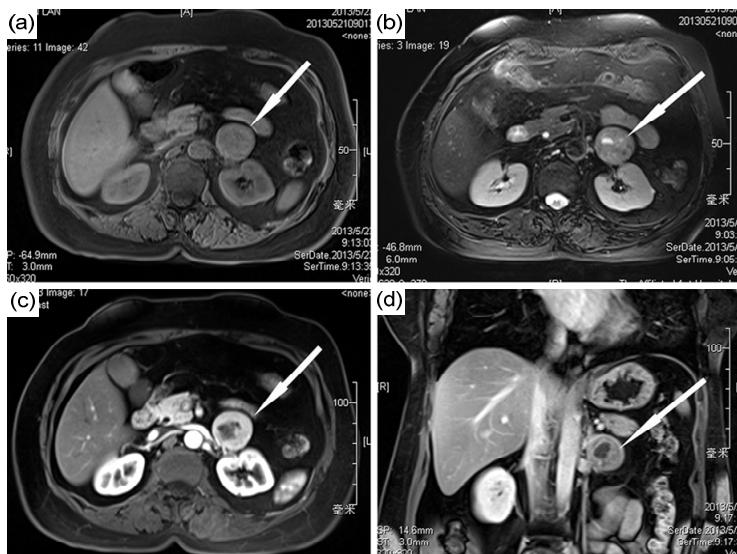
Contrast-enhanced magnetic resonance imaging of upper abdomen
